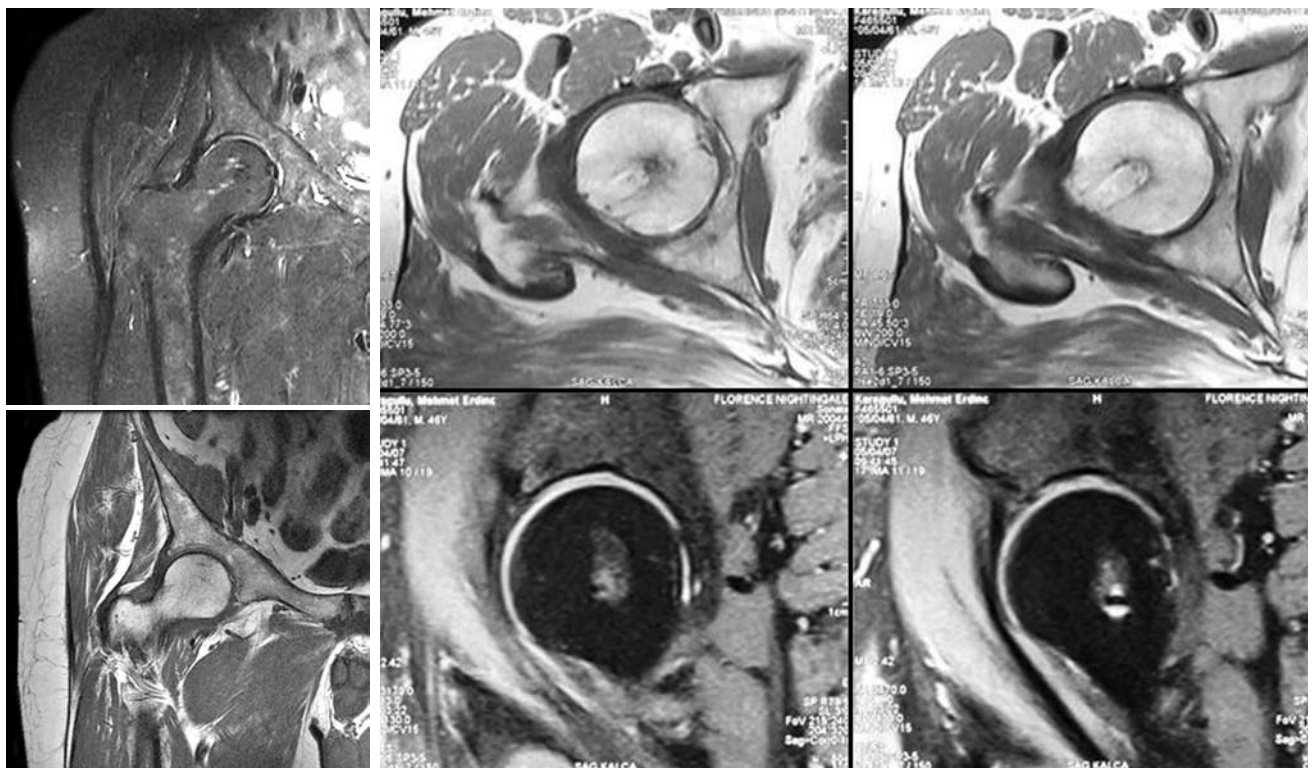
Core decompression and autologous mononuclear bone marrow cell implantation performed. MRI of after 24 months. He was evaluated as stage 0.
